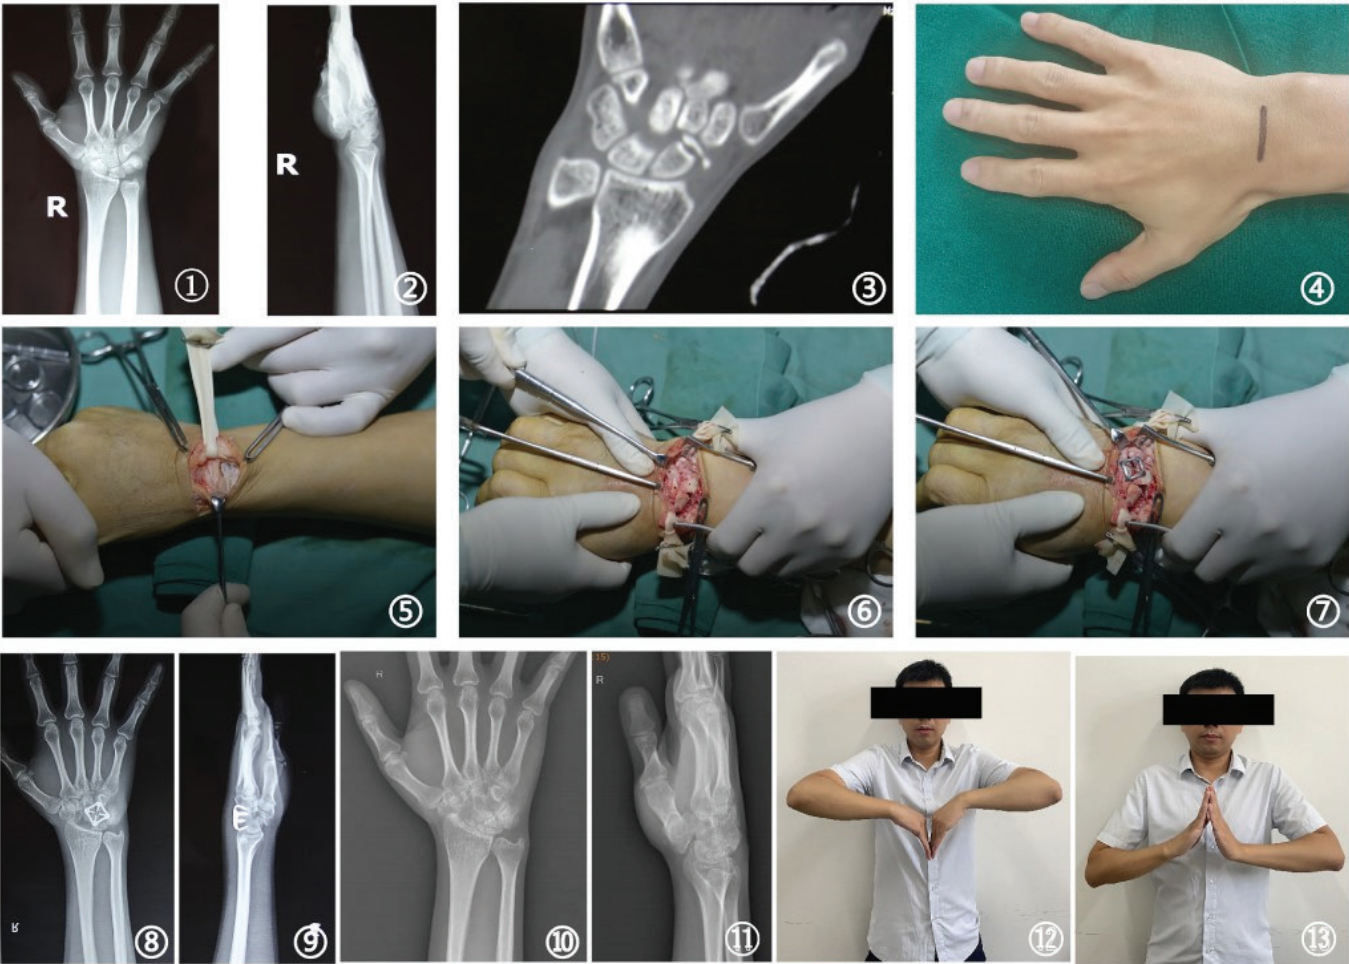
Preoperative right wrist joint anterior-posterior X-ray. Figure 2: Preoperative right wrist joint lateral X-ray. Figure 3: Preoperative right wrist joint CT scan. Figure 4: Transverse incision at the dorsal aspect of the right wrist. Figure 5: Exposure of the joint capsule and wrist bones. Figure 6: Removal of the scaphoid bone and drilling at the center of the wrist bones requiring fusion. Figure 7: Implantation of NT-FCAC. Figure 8: Postoperative 1-month right wrist joint anterior-posterior X-ray. Figure 9: Postoperative 1-month right wrist joint lateral X-ray. Figure 10: Postoperative 14-year right wrist joint anterior-posterior X-ray. Figure 11: Postoperative 14-year right wrist joint lateral X-ray. Apologies for the confusion earlier. Figure 12: Image of patient's right wrist joint flexion function 14 years postoperation. Figure 13: Image of patient's right wrist joint extension function 14 years postoperation.
